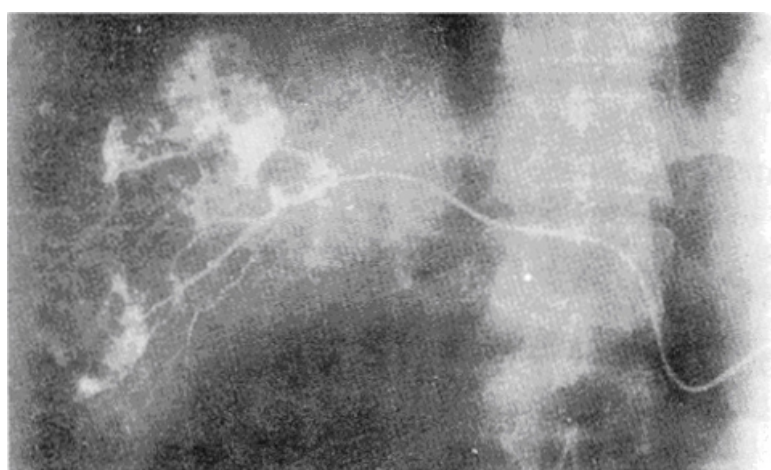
Radiograph by immediate visualization of tumor body after injection intubation of hepatic artery branch.
